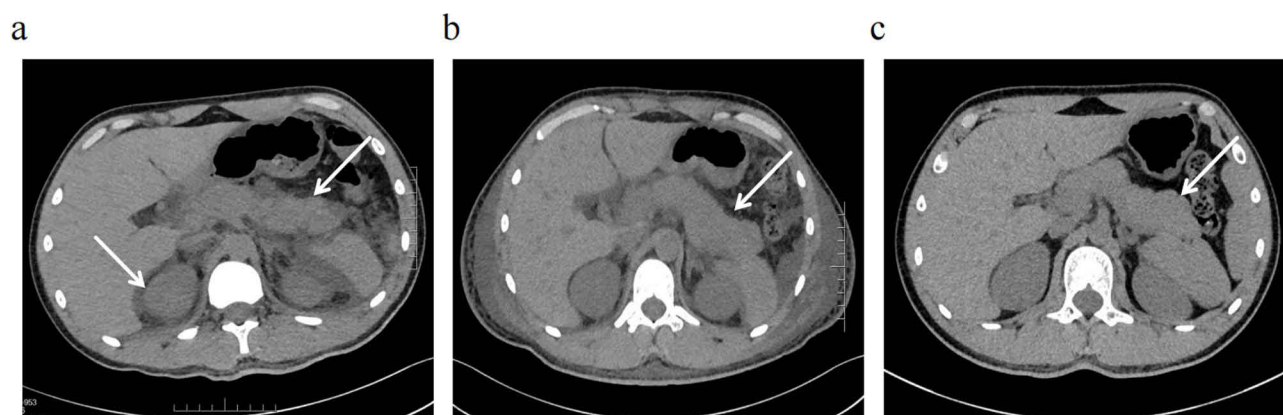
Abdominal computed tomography scans on day 3 POS. (a), day 12 POS (b), and day 42 POS (c). (a) Acute pancreatitis was accompanied by significant pancreatic swelling, peripancreatic and perirenal effusion, left arrow point perirenal effusion, right arrow point peripancreatic effusion; (b) A improvement in pancreatic, peripancreatic and perirenal changes, the arrow point peripancreatic effusion improvement; (c) Pancreatic and peripancreatic changes were nearly to the normal, the arrow points pancreas.
